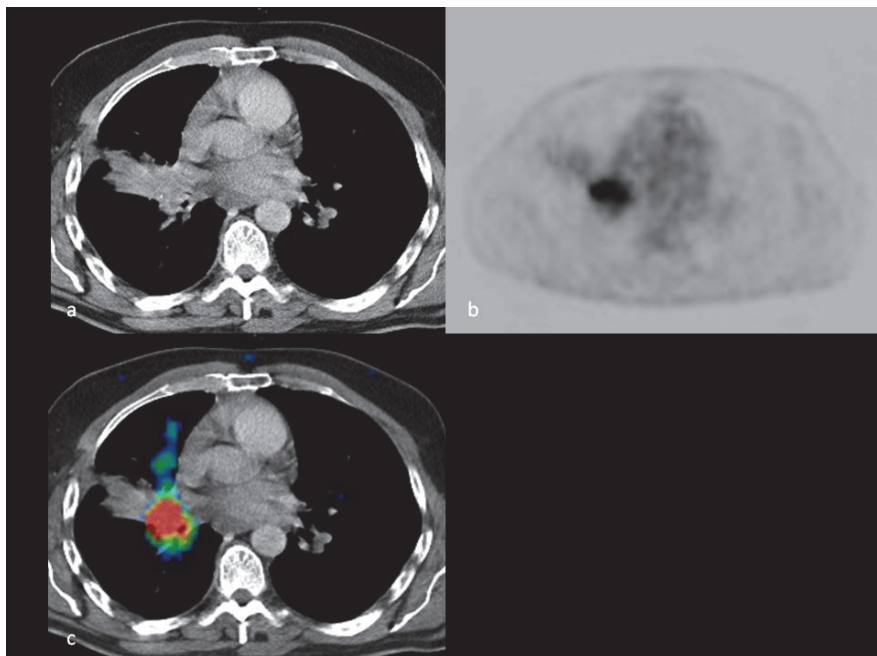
A 57-year-old man with a central tumor in the right lung. CT demonstrates a central mass with a retro-obstructive consolidation in the right upper lobe (fig 2a). PET demonstrates FDG uptake in the right hilar region corresponding with the central tumor (fig 2b). Integrated PET/CT demonstrates the central tumor in the right lung and can delineate the tumor from the surrounding retro-obstructive consolidation in the right upper lobe (fig 2c).
